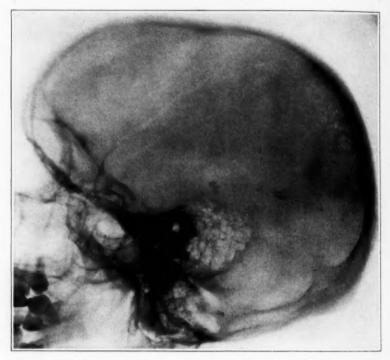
(case 4).—Roentgenogram of the skull, showing multiple areas of intracranial calcification (particularly in the occipital region).
